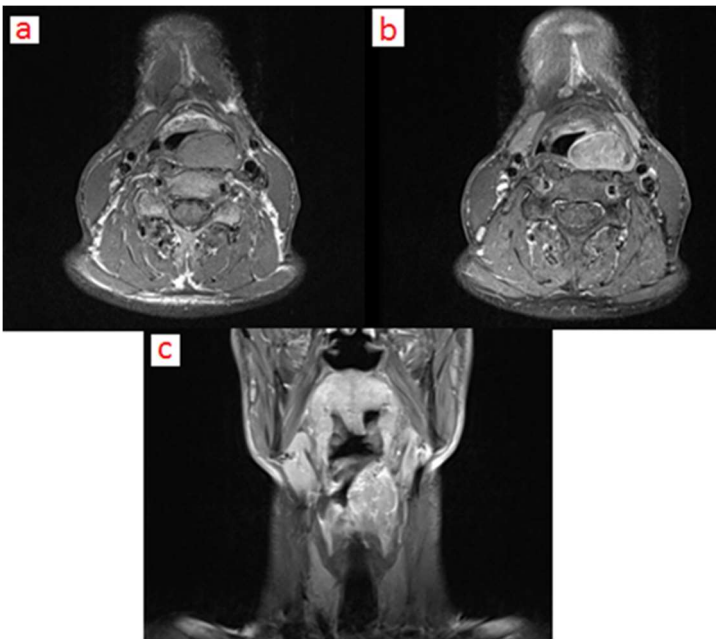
Extra-cardiac rhabdomyoma located at left hypopharynx extending into parapharyngeal space superiorly a. T1 weighted axial MRI scan b.T1 weighted axial scan with contrast c.T2 weighted coronal scan.
